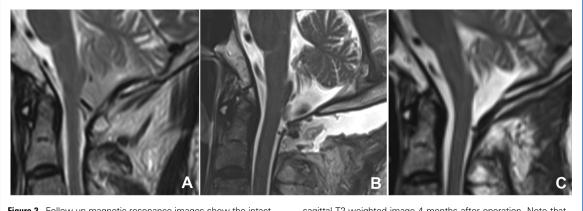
Follow-up magnetic resonance images show the intact medulla oblongata and upper cervical cord. (A) Preoperative sagittal T2-weighted image. (B) Postoperative sagittal T2-weighted image 12 days after operation. (C) Follow-up
